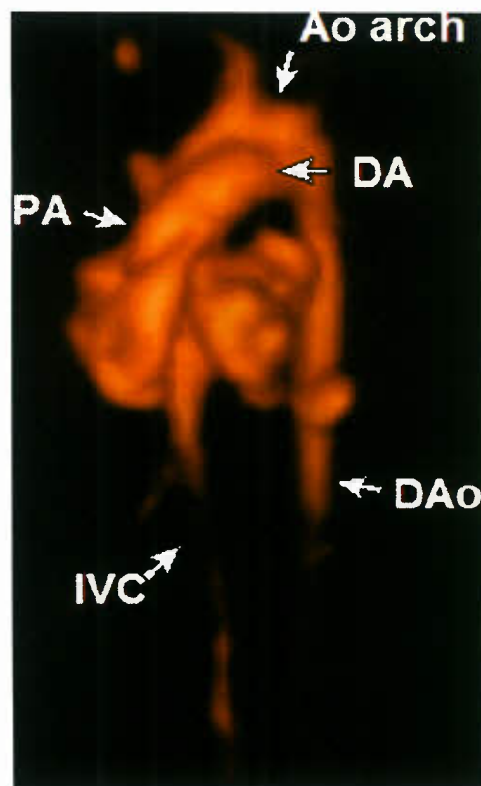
Rendered STIC image of aortic and ductal arches obtained from STIC dataset recorded with B-mode documentation of cardiac and vessel blood flow. (Reproduced from Gonçalves LF, Lee W, Espinosa J, et al. How do we do it? Practical advice on imaging-based techniques and investigations. *Ultrasound Obstet Gynecol* 2006;27(3):336–348, with permission from John Wiley and Sons.)
